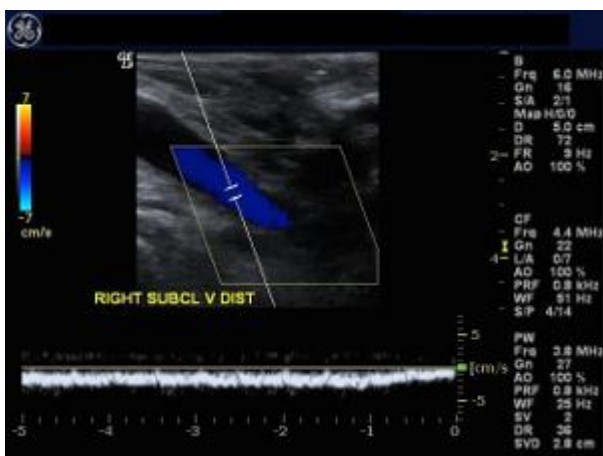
Color and Spectral Doppler image of Distal Right Subclavian Vein
